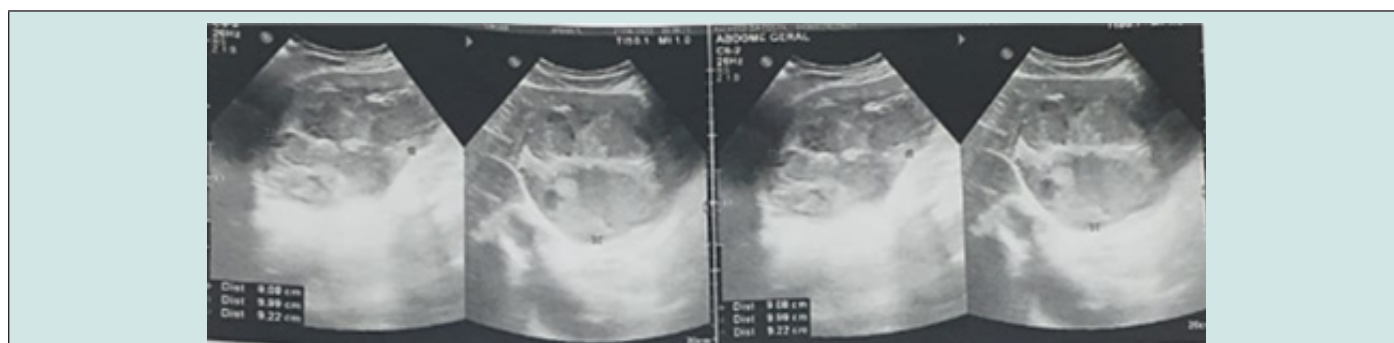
Ultrasonography of the whole abdomen evidence of a hypoechoic nodule in the left hepatic lobe with coarse septations measuring 10 x 9.0 x 9.0 cm, suggestive of a liver abscess.
